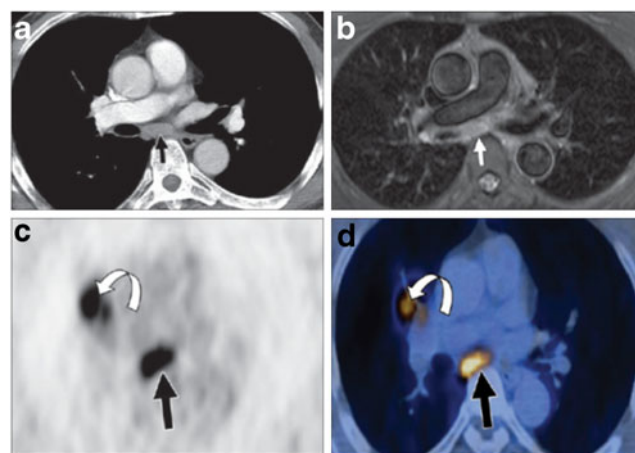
X-ray CT of stage T₂ adenocarcinoma at level of bronchus intermedius. Arrow shows tumor location. Slice thickness=5 mm. b T₂-weighted MR image at same location as X-ray CT image. Arrow shows tumor location. c ¹⁸F-FDG PET image of same anatomical location. Tumors (colored black) stand out because of higher uptake of ¹⁸F-FDG. Note the lack of anatomical information. d PET image superimposed on CT image showing anatomical landmarks. Reproduced from [31]
